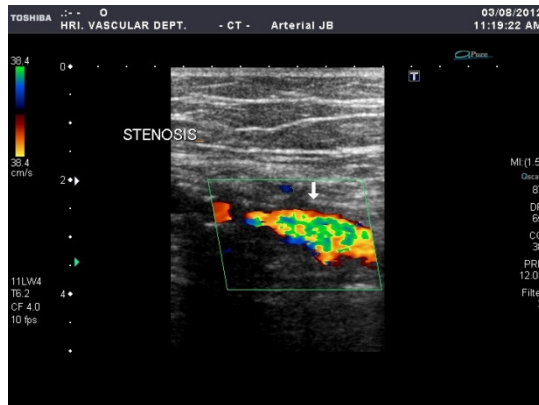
Ultrasound duplex of turbulent flow secondary to a stenosis
